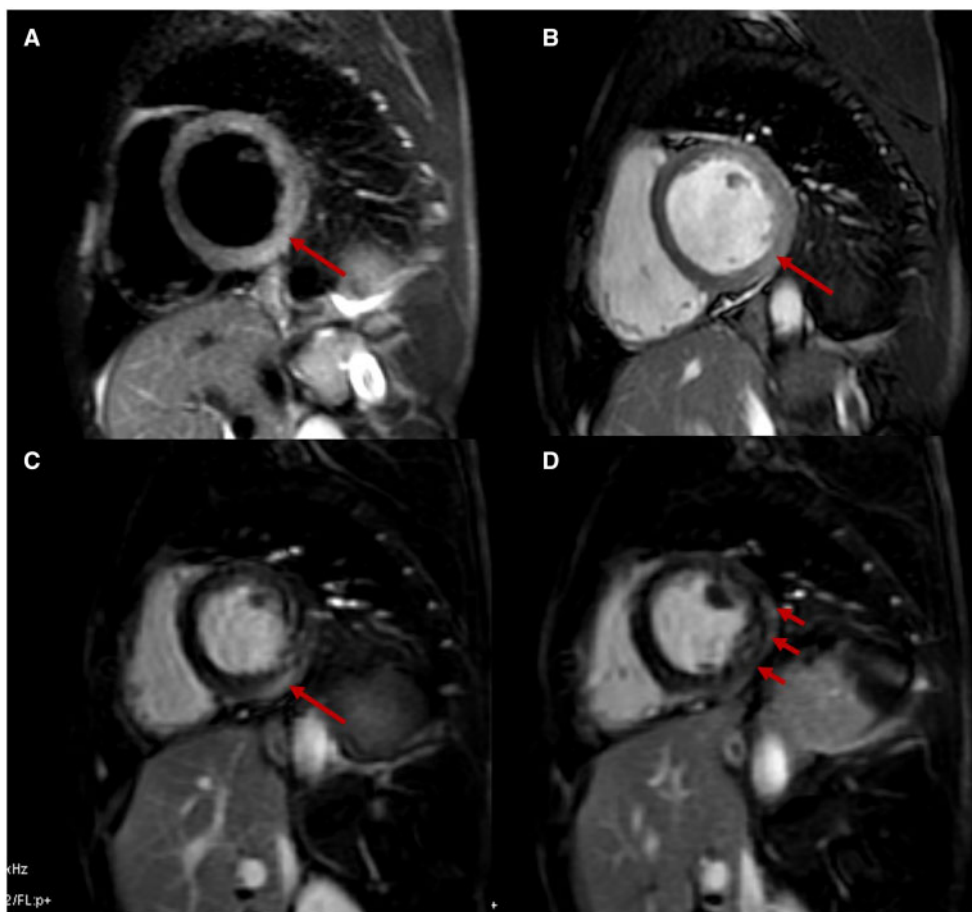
CMR confirming the diagnosis of myocarditis. Black blood T2-weighted with fat saturation image (A) and post-gadolinium SSFP image (B) in short-axis view showed diffuse myocardial signal hyperintensity involving the posterolaterobasal wall of the left ventricle, suggesting interstitial oedema. Myocardial damage was confirmed on the late gadolinium enhancement involving the subepicardial layer of the myocardium (C and D). Pericardial enhancement (D) and pericardial effusion were seen around the laterobasal wall of the left ventricle ([Supplementary material online, Video S1](#)), suggesting pericardial oedema.
